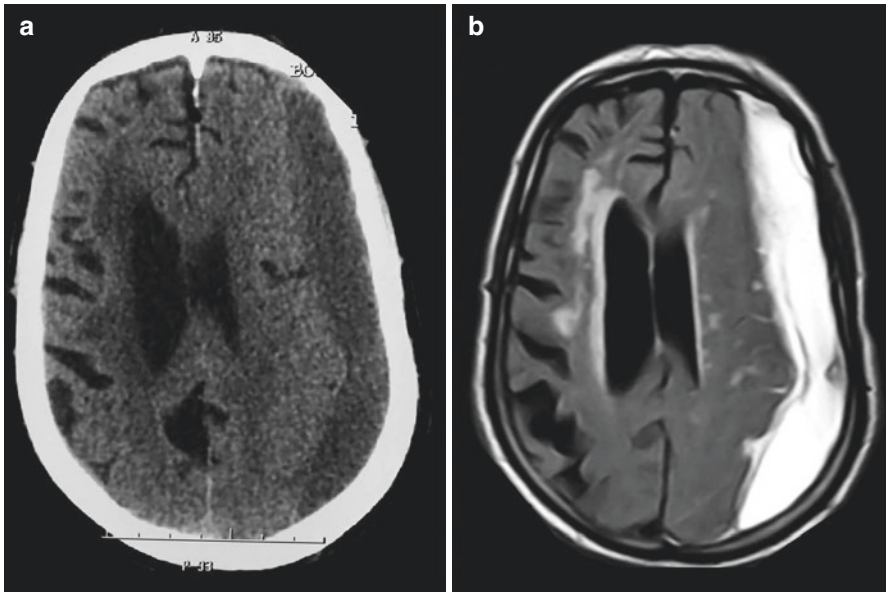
Intracranial chronic SDH on the left side in the same patient on axial CT scan (a) and inversion recovery sequence (MRI) (b)
